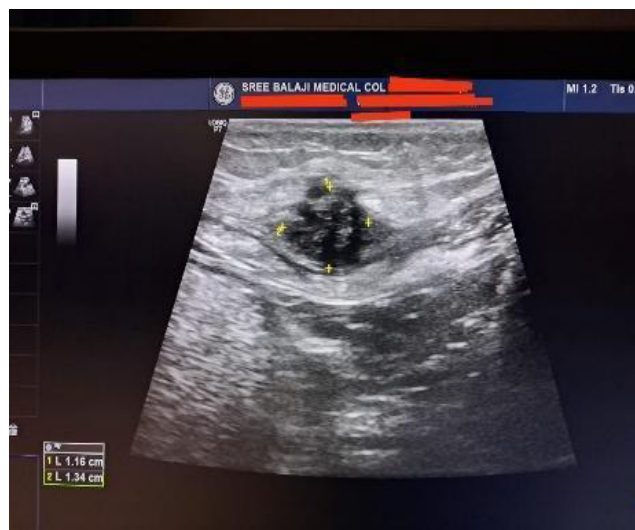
Ultrasound image and report of scar endometriosis
